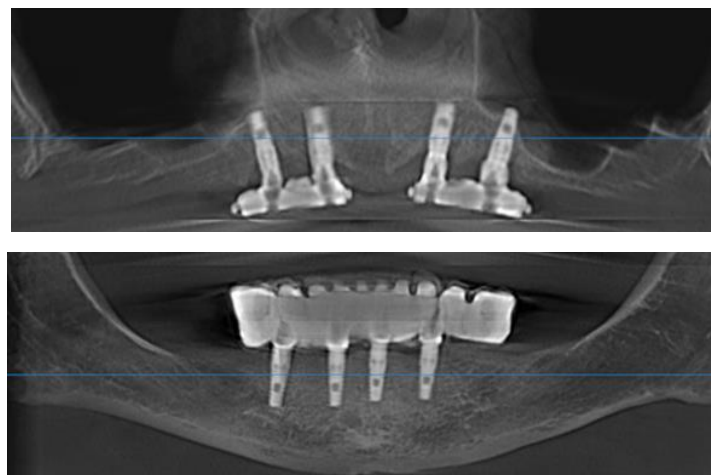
Radiograph image with the appliances
